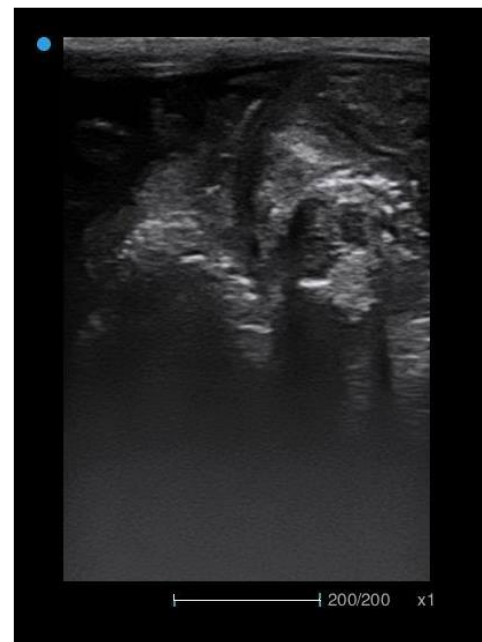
Sonographic view of fetuses before referring to surgery
